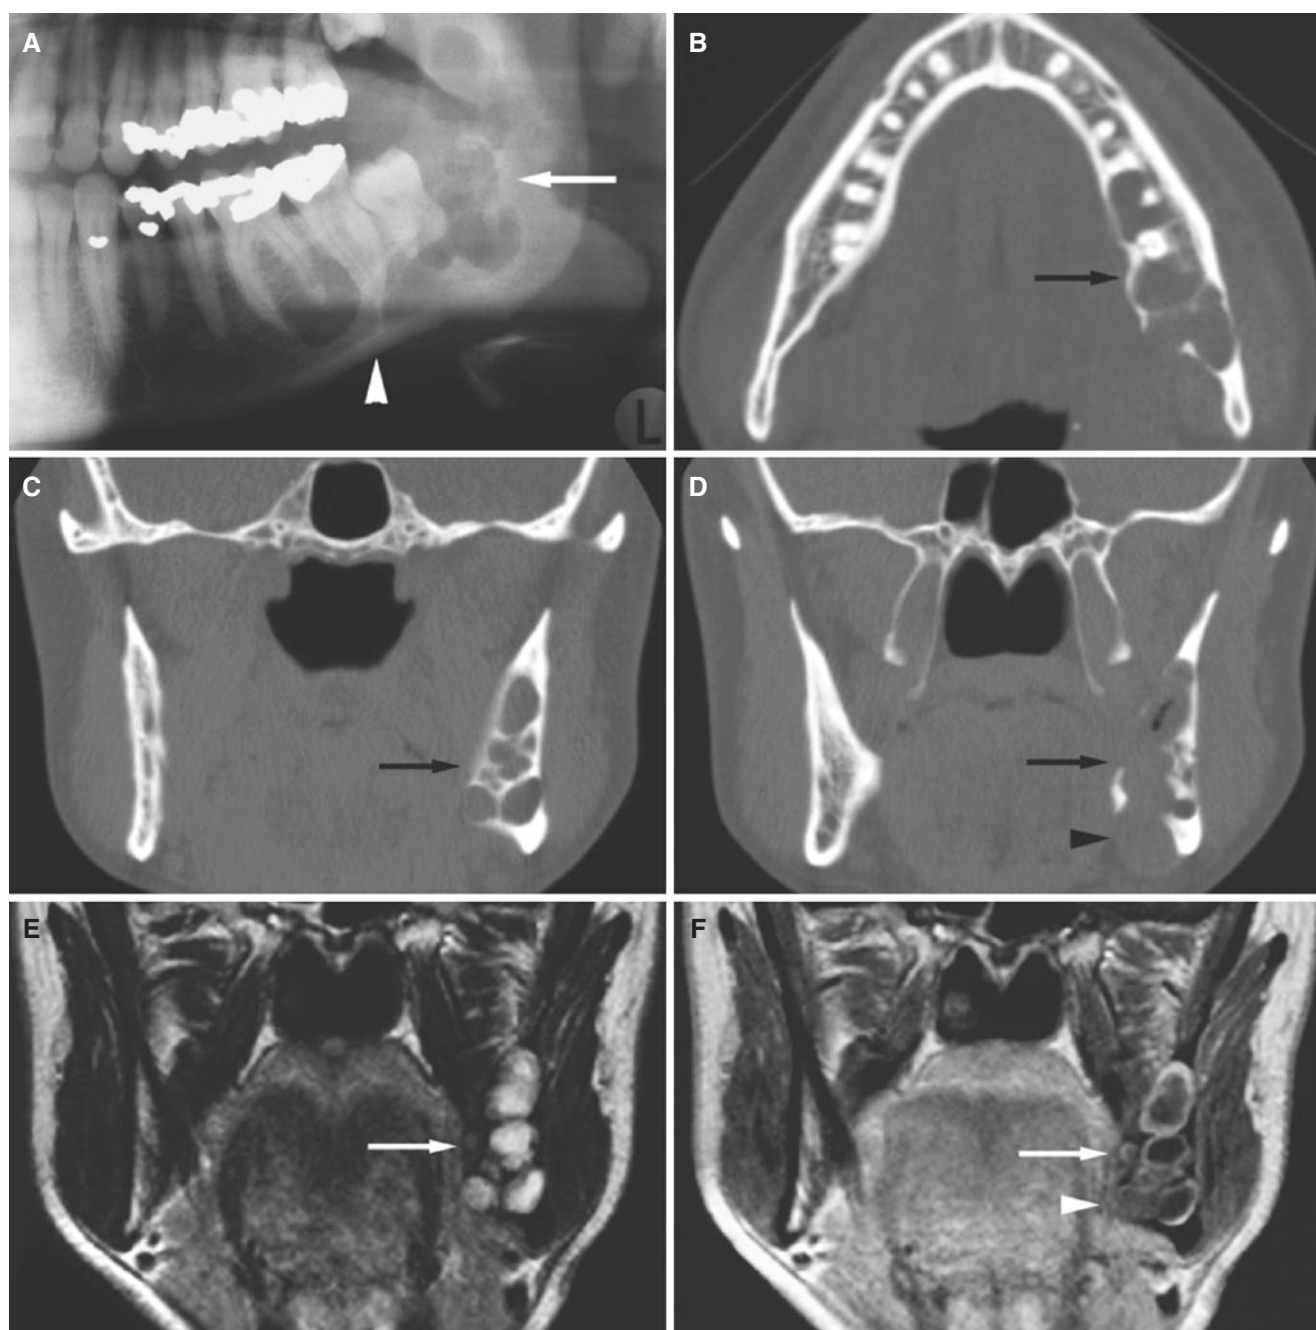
Mucoepidermoid carcinoma, mandible; 46-year-old male with incidental finding at routine dental radiography of impacted wisdom teeth. (A) Panoramic view shows multilocular radiolucency (arrows) with intact mandibular border (arrowhead) and impacted third molar. (B) Axial CT image shows multilocular radiolucency (arrow) with defect in lingual cortical bone. (C) Coronal CT image shows multilocular radiolucency (arrow). (D) Coronal CT image shows bone destruction lingually (arrow); note in particular at the lower mandibular border (arrowhead). (E) Coronal T2-weighted MRI shows high signal in multilocular process (arrow). (F) Coronal T1-weighted post-Gd MRI
